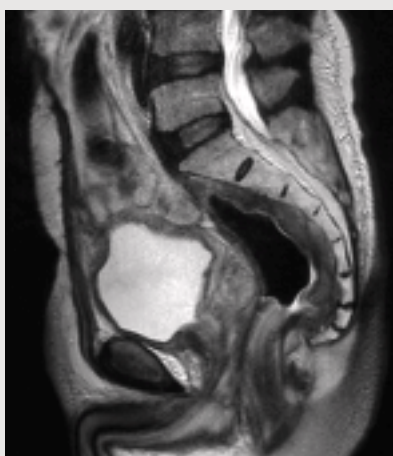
T2-weighted images
